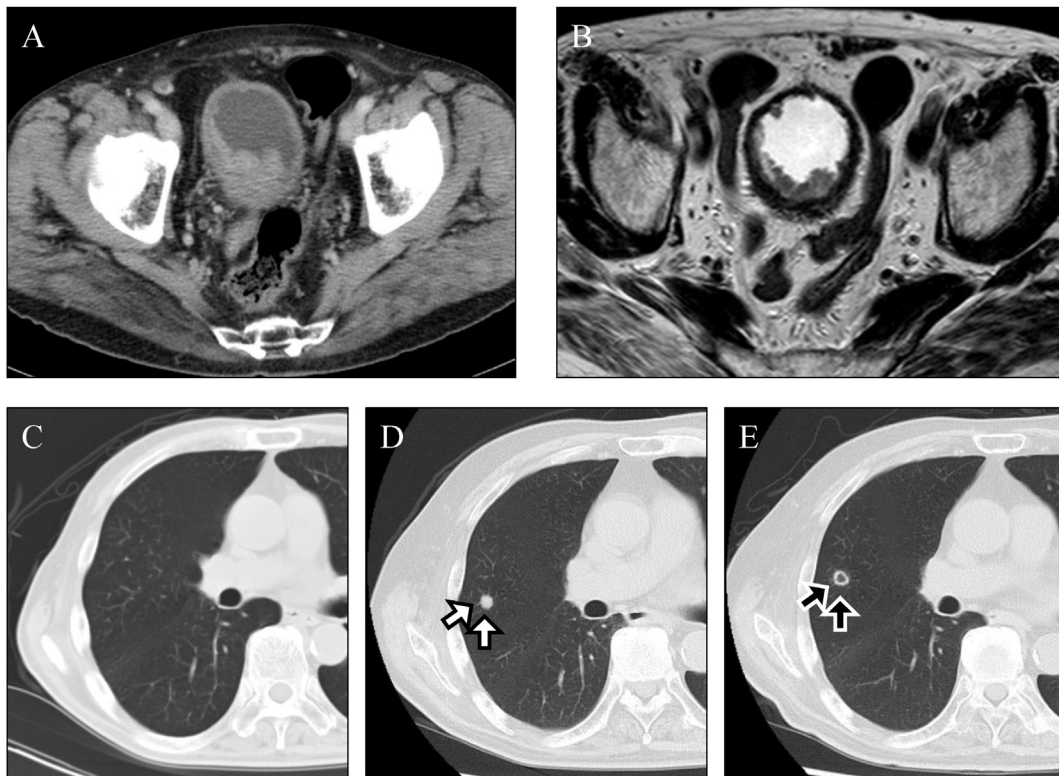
A, B, Abdominal enhanced CT (A) and T2-weighted MRI (B) showed multiple advanced-stage bladder tumors that were 3 cm in maximum diameter. C, Plain CT of the chest demonstrated the absence of metastatic lesion in radical operation. D, Chest CT revealed a solitary 8 mm-sized nodule in the right middle lobe of the lung, 3 years after radical operation (white arrow). E, Chest CT revealed that the inner signal of the metastatic lesion had turned rough after 6 cycles of induction chemotherapy (black arrow).
